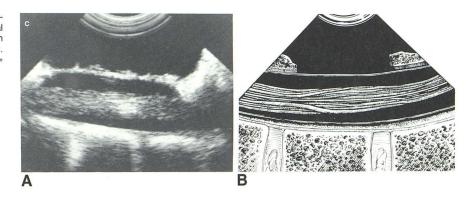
Normal proximal cauda equina. Longitudinal IOSS (same patient as in fig. 5). Along central acoustical axis, higher level echoes are seen when compared with more peripheral parts of sonogram. Roots of cauda equina are identified clearly. C= cephalad.
